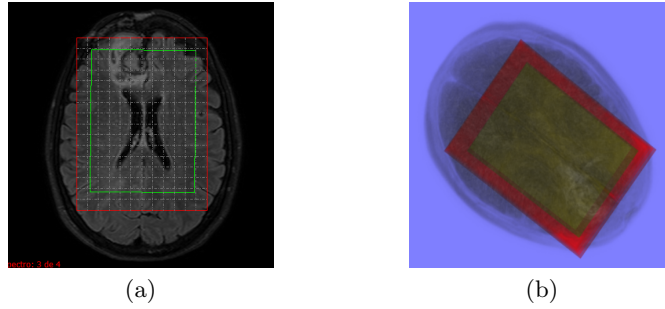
MRI-CSI registration:(a)FOV and VOI over anatomical image, (b) MRI-CSI 3D view.
